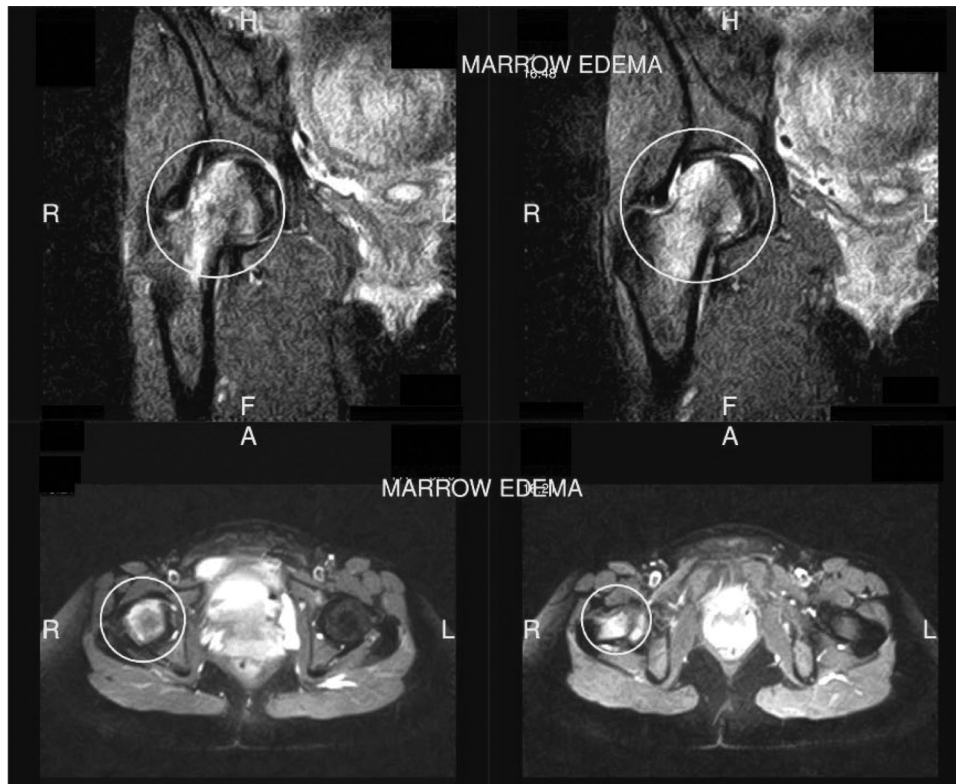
Coronal and axial T2 fat saturated MRI images of the right hip in a pregnant patient who is 28 weeks pregnant with transient osteoporosis of the hip.
